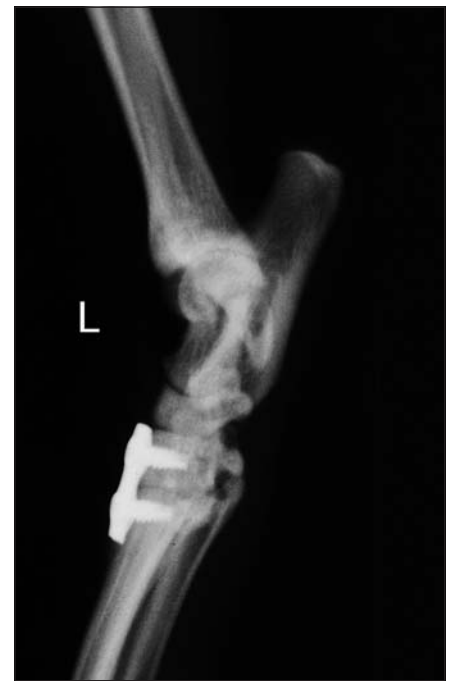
Dorso-plantar view of the left tarsus, postoperative radiograph.
